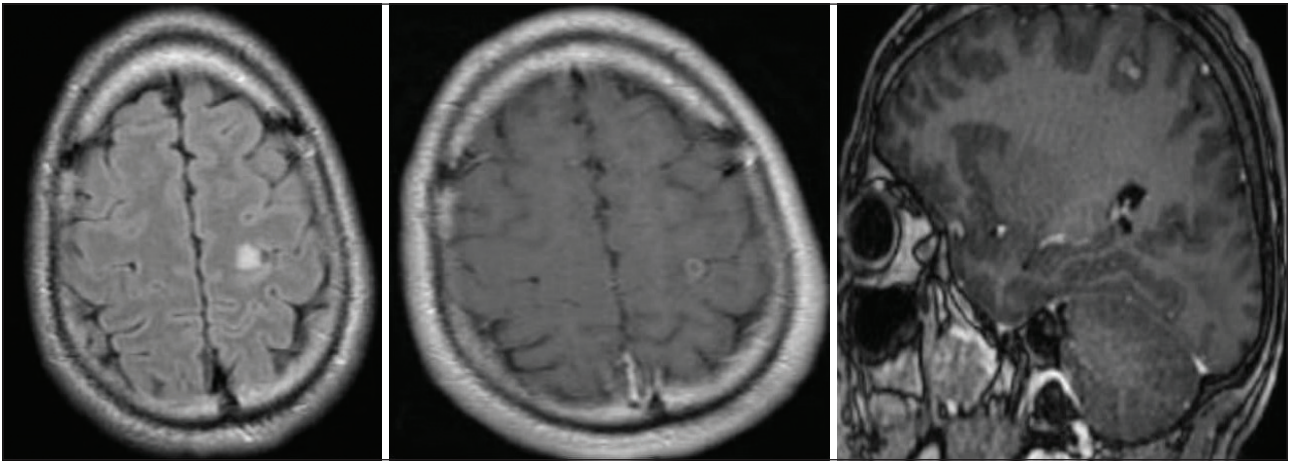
Brain MRI showing inflammatory granuloma in the left frontal region. (A) Flair images showing hyperintense focus over the left precentral gyrus. (B) T2 post contrast showing inflammatory granuloma over the left precentral region. (C) Sagittal images showing ring-enhancing lesion over the left frontal region.
